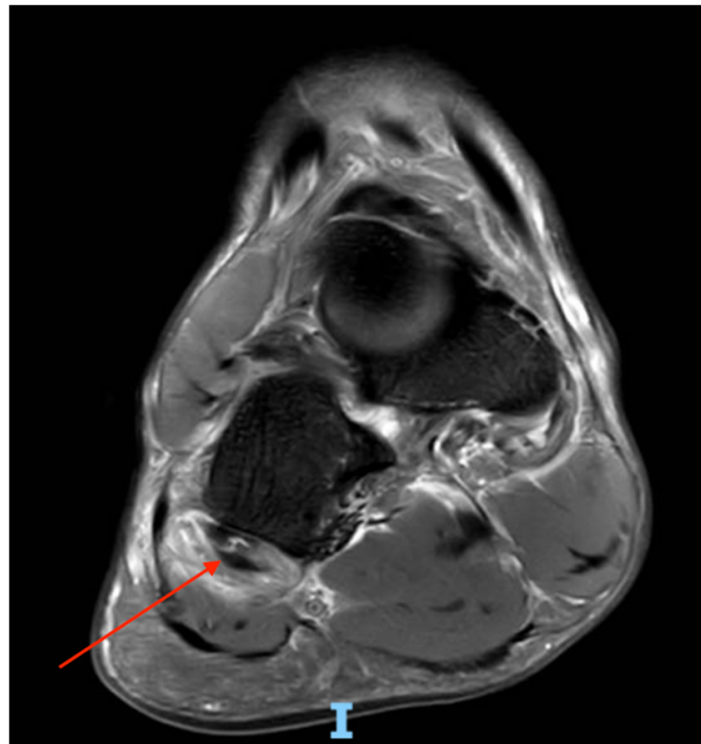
MRI of right ankle (T2 PDFS coronal): longitudinal tear (red arrow) of peroneus longus tendon with intratendinous hyperintensity and fluid.
